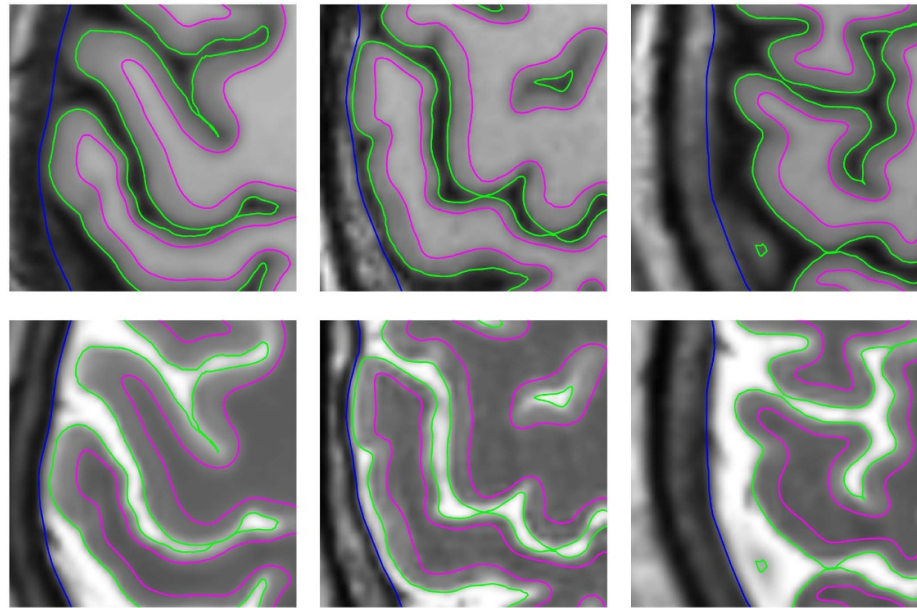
Segmented WM-GM (magenta), GM-CSF (green) and CSF-skull (blue) surfaces overlaid on top of T1-weighted (top) and T2-weighted (bottom) MR images centered around target region. The images are of axial plane slices of participants 1, 2 and 4 (left to right).
